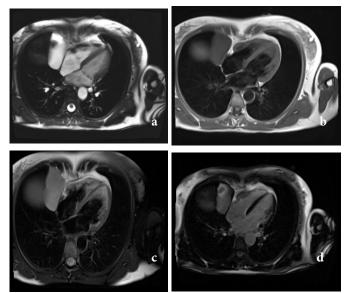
CMR showing pericardial cyst measuring 8.2 x 3.4 x 3.3 cm (a. cine-MR image, b. T1w image, c. T2w image, d. LGE)
